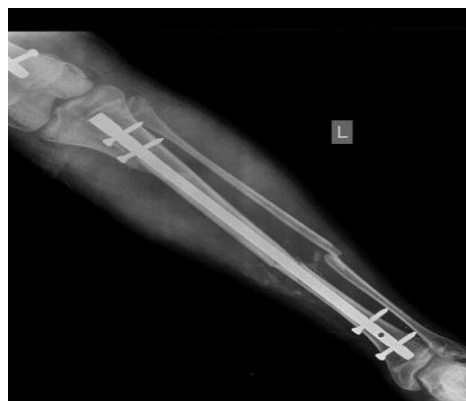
Postoperative anteroposterior (AP) radiograph of the tibia
